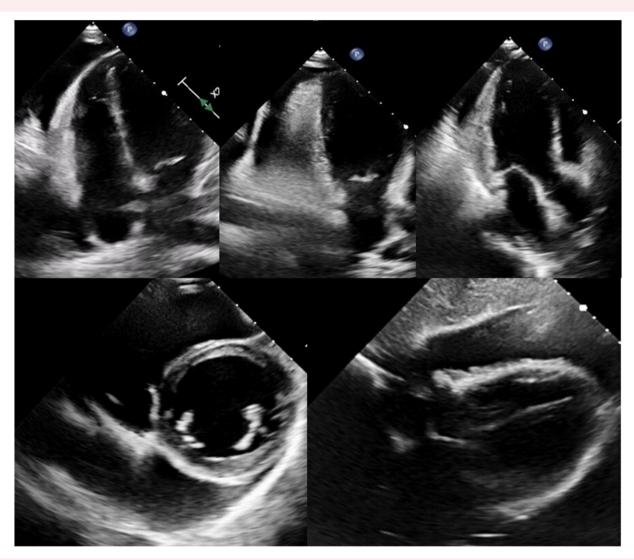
Initial echocardiography (line above: apical four-, two-, and three-chamber views; line below, parasternal short axis at papillary muscle level and subcostal view) showing relevant circumferential pericardial effusion, partly organized.
